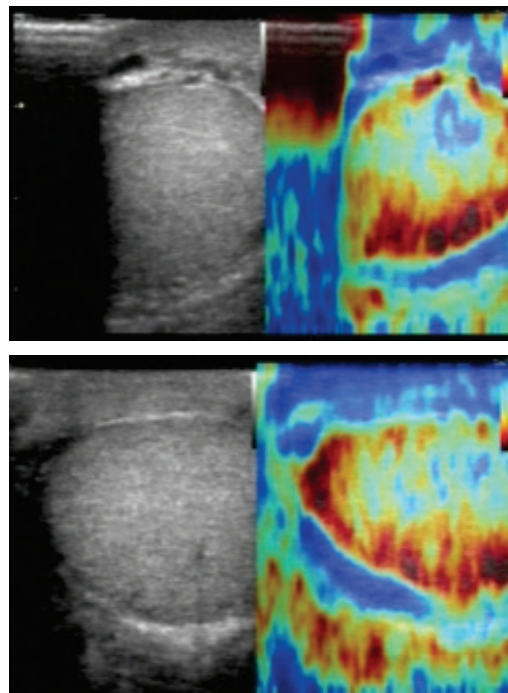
Ultrasound examination with Doppler and elastography of the right and left testicles of a patient with obstructive azoospermia
